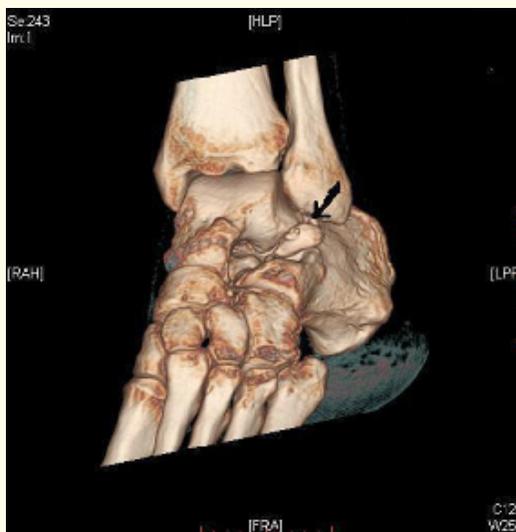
CT shows non union of the fracture.
